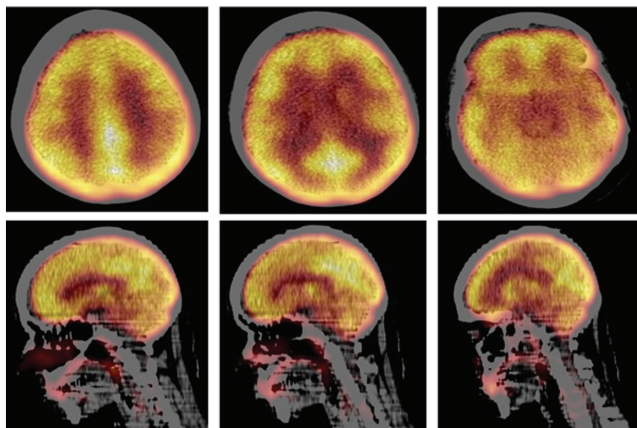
Cranial FDG-PET/CT fusion images of a 46-year-old female patient (top row: transaxial sections from the vertex towards inferior; bottom row: sagittal sections): There is no decrease in frontal cortex FDG uptake and it is appear to be normally (Frontal cortex SUV_{mean} = 0.81). HADS-A and HADS-D scores were found 9 and 6, respectively.
